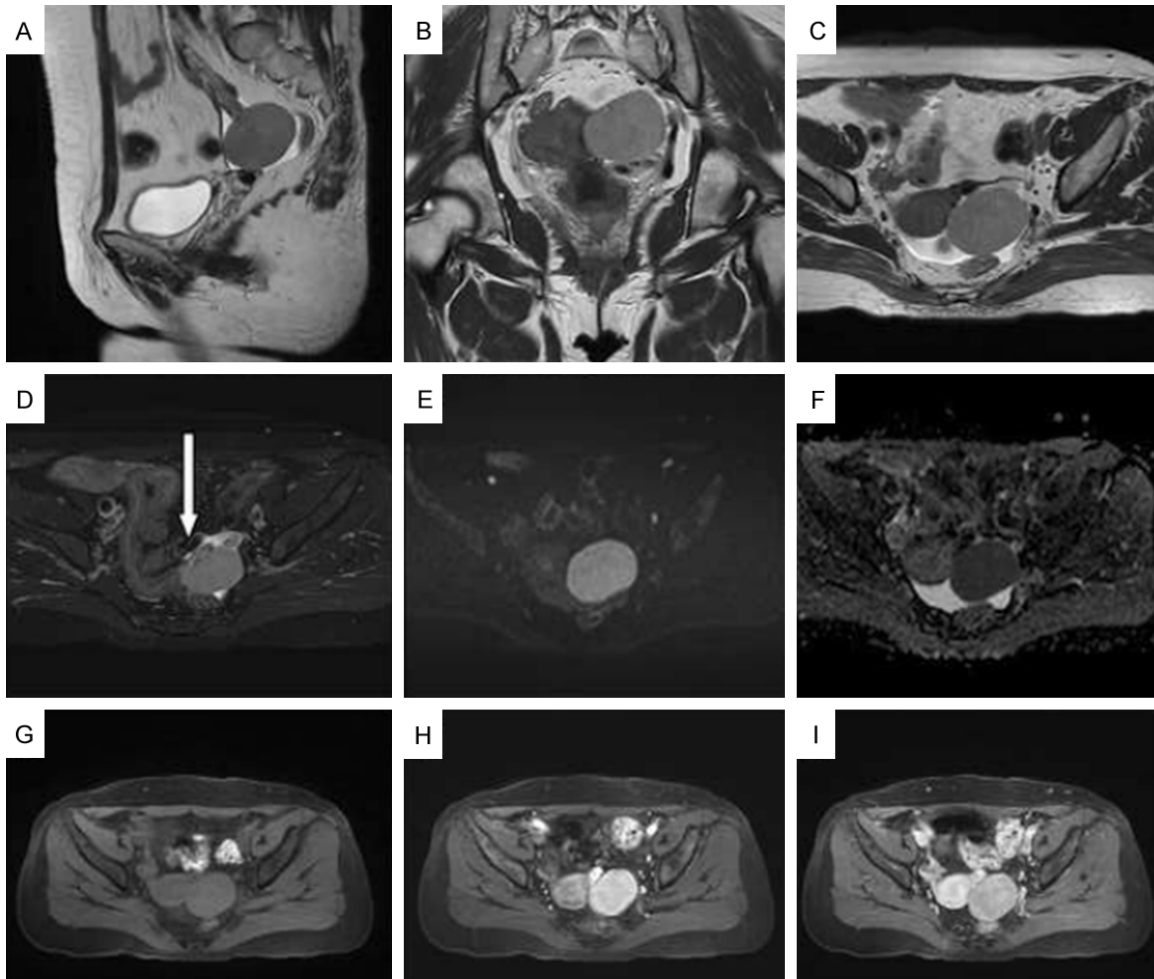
Magnetic resonance imaging. A-D: Sagittal, coronal, and transverse T2-weighted imaging (T2WI) images show an isolated soft-tissue mass in the left ovary, measuring 4.5×4.0 cm, with a clear boundary. On T2WI, the mass appears slightly higher in position and uniform, surrounded by thick, hollow vascular shadows (white arrow); E, F: Limited diffusion on diffusion-weighted imaging (DWI) and low signal on apparent diffusion coefficient (ADC). The ADC value was $0.72 \times 10^{-3} \text{ mm}^2/\text{s}$; G-I: T1-weighted imaging (T1WI) showing a uniform isointense signal on a plain scan. Enhancement was uniform in the early stage and then withdrew in the late stage, presenting with a rapid outflow pattern.
